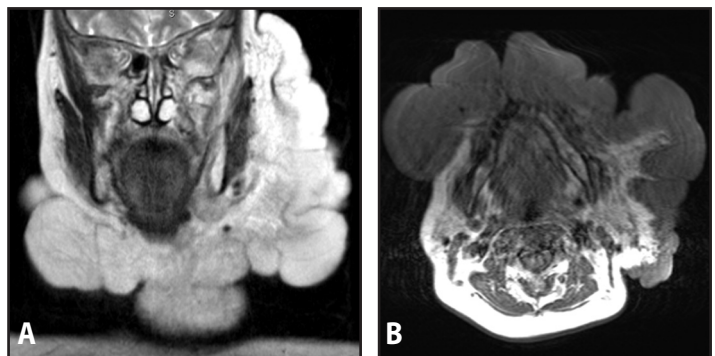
Magnetic resonance imaging: A. Coronal view at the level of the maxillary sinuses showing high signal intensity on T2 weighted images; and B. Axial view at the level of the mandible showing intermediate signal intensity on T1 weighted images
